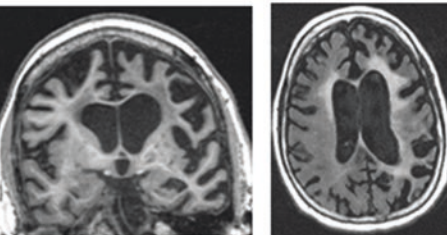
(Continued) and/or temporal predominant hypometabolism on the FDG-PET scans. Also note that the topographic distribution of atrophy and hypometabolism is relatively symmetric, which is typical of affected *MAPT* mutation carriers. The scans in (b) are from symptomatic *GRN* mutation carriers: A9D (age 72 with mixed PPA/bvFTD features for 3 years), Y294X (age 70 with bvFTD features for 3 years), T52fs (age 68 with early amnesic features followed by PPA and then CBS features evolving
